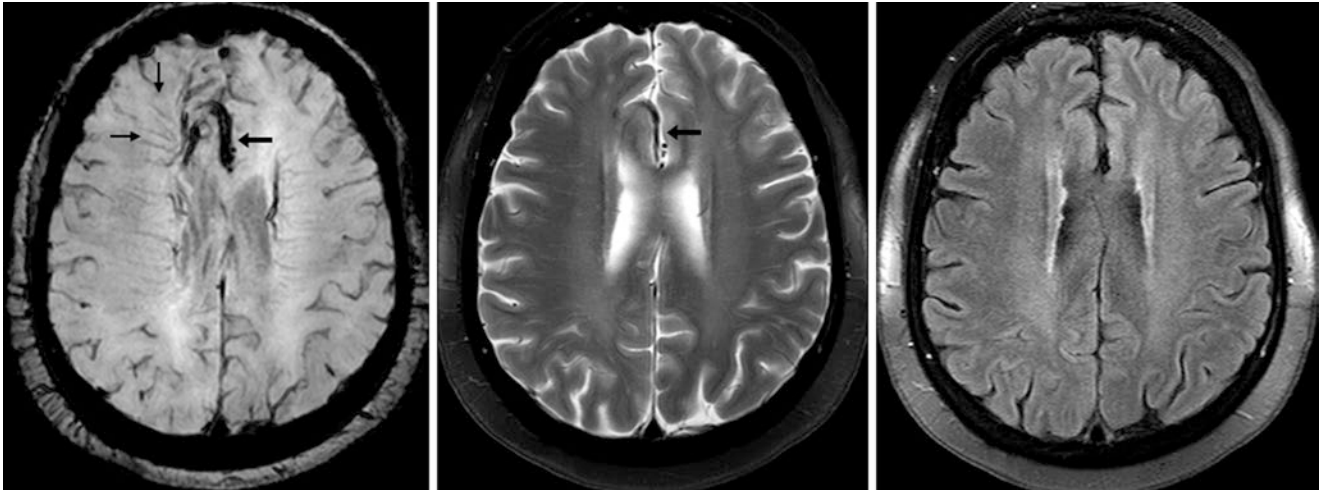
A 77 year old with headaches in whom a 3T MRI with SWI (*left*) demonstrated a very large DVA that had quite a prominent draining vein (*arrows*) that drained a caput of smaller vessels (*thin arrows*). This enlarged vein is only partially visible on T2WI (*middle*) and is
